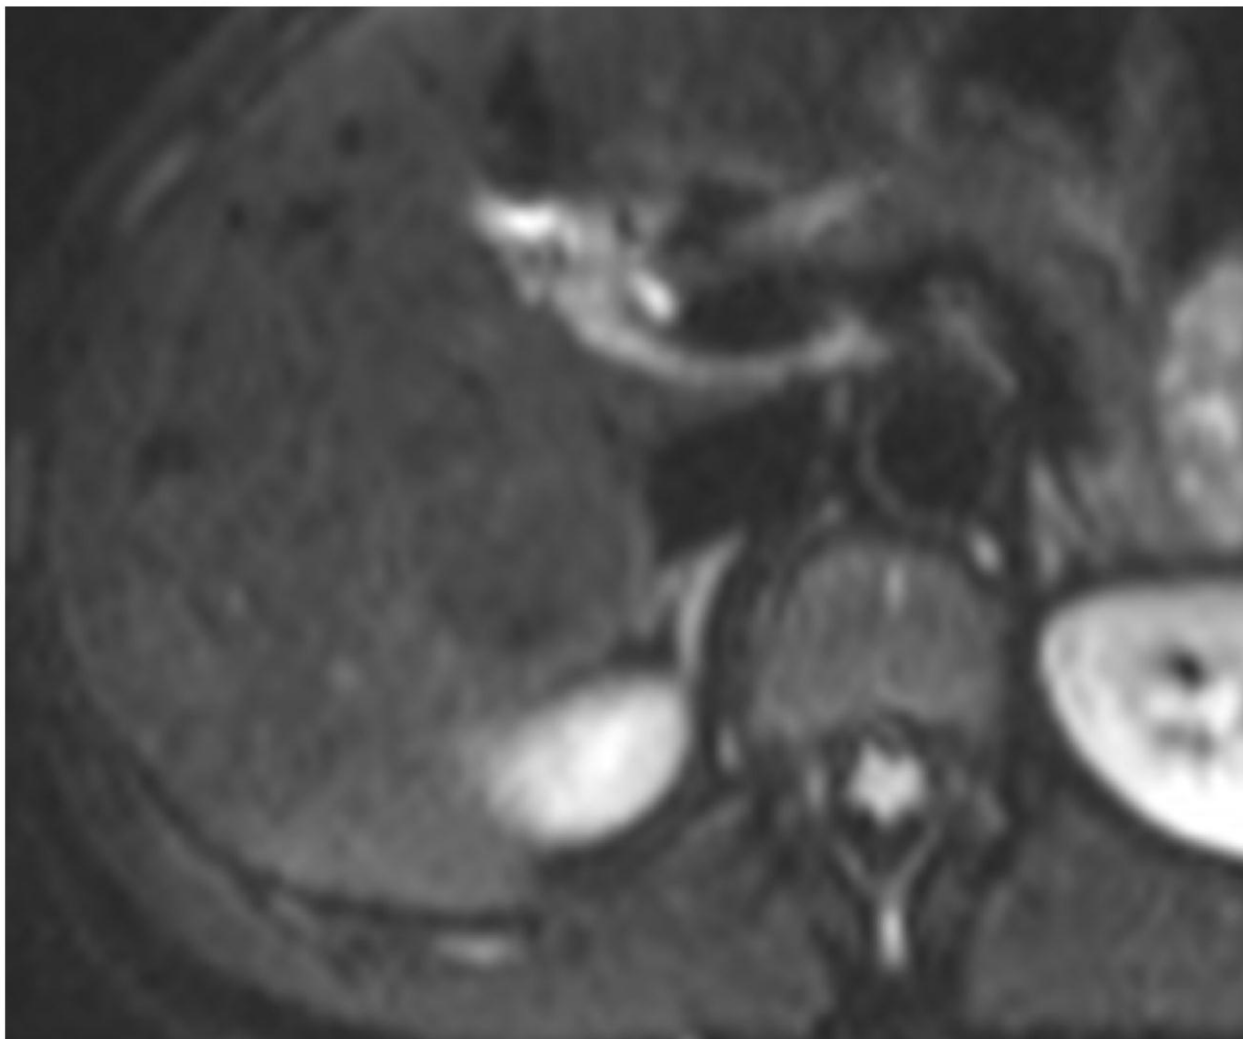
DW MRI. The same female patient. HA shows no restricted diffusion at b-value=50.
